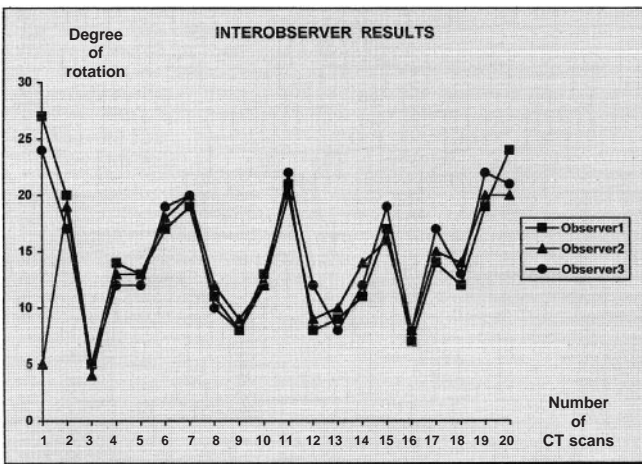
Inter-observer measurement results of the new CT measurement method
